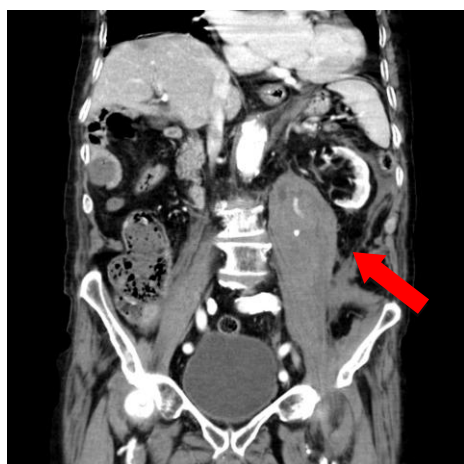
A CT scan of the abdomen showing an active contrast extravasation (marked with the arrow) on left psoas muscle, suggestive of ongoing bleeding
